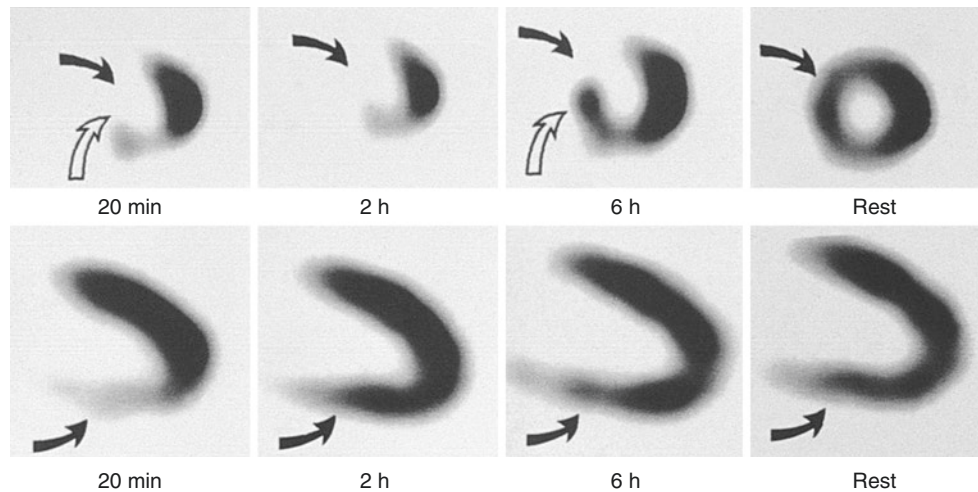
Clinically relevant change in the defect size of ^{99m}Tc -sestamibi with time (redistribution) in two patients who experienced exercise ^{99m}Tc -sestamibi studies. Myocardial SPECT images obtained from two different patients are presented in the short-axis plane (*top row*) and in the vertical long-axis plane (*bottom row*) after exercise and at rest. In the short-axis plane, there is no change in ^{99m}Tc -sestamibi defect size from 20 minutes to 2 hours after exercise, but by 6 hours there is a significant change in the defect size in the inferoseptal region
